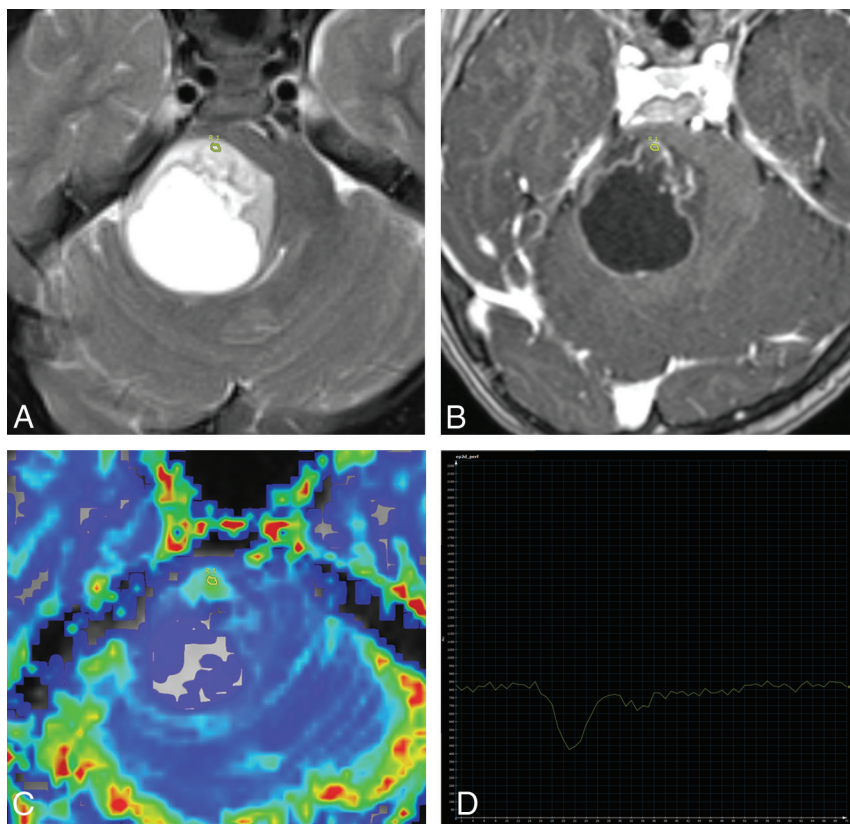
Axial T2 (A), axial T1-weighted postcontrast (B), axial DSC perfusion CBV map (C), and tissue signal-intensity time curve (D) of a glioblastoma. The tumor has T2 hyperintensity, cystic change, and minimal heterogeneous enhancement and has well-circumscribed margins suggesting a low-grade neoplasm such as a pilocytic astrocytoma. However, the TSITC from an ROI with the highest tumoral rCBV demonstrates a return to baseline pattern, which is highly sensitive for a high-grade tumor; there is low probability that this represents a pilocytic or pilomyxoid astrocytoma.
